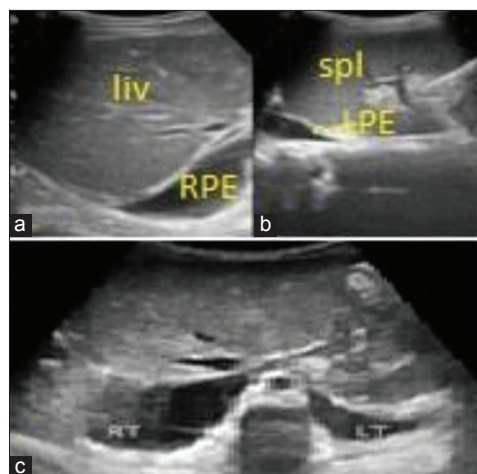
(a) Right pleural effusions; (b) Left pleural effusion and (c) Bilateral pleural effusions as ultrasound warning signs of capillary leakage
